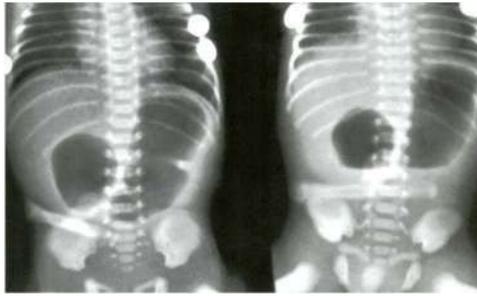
Duodenal atresia – X-ray showing a "double bubble" appearance.
